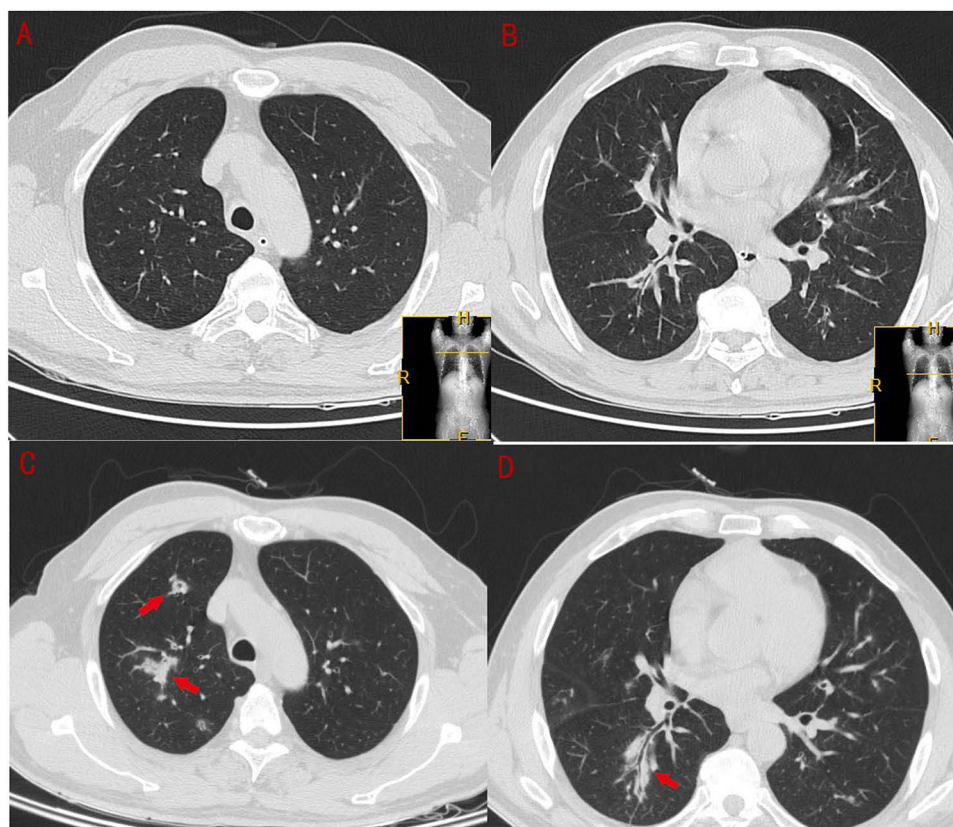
(A and B) show the patient's CT scans at the time of admission, with no significant abnormalities observed. (C and D) depict the chest CT after 7 days, revealing thickened bronchial walls and surrounding exudative lesions (the area indicated by the red arrow).
